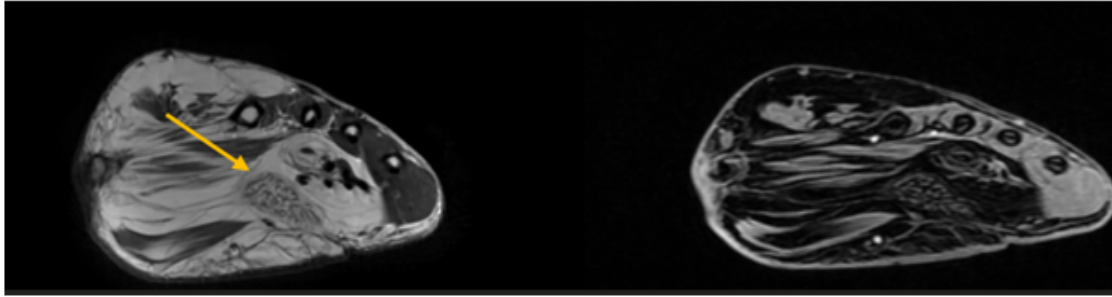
Axial MRI of the hand in T2 and T2 STIR sequences showing enlargement of the palmar fat pad infiltrating the muscles and nerves, with enlargement of the median nerve presenting serpentine fascicles, producing the characteristic “spaghetti-like” appearance (Yellow arrow).
